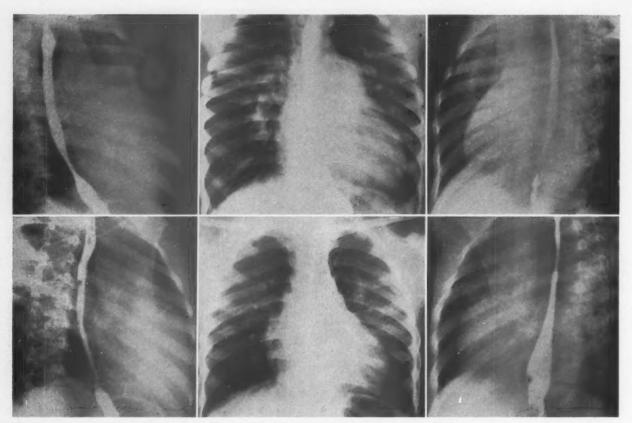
Case 34. Roentgenograms before operation (top row) indicate pulmonary hypervascularity, prominent pulmonary artery trunk and hilar vessels, moderate left ventricular enlargement and questionable left atrial enlargement. Roentgenograms fourteen months postoperatively (bottom row) show diminished prominence of the pulmonary artery trunk, heart chambers unchanged; hypervascularity formerly present has disappeared along with the prominent hilar vessels.
